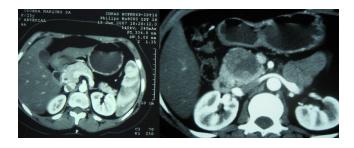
CT scan showing a 4.2 x 4.0 cm heterogeneous solid–cystic mass in the pancreatic head
